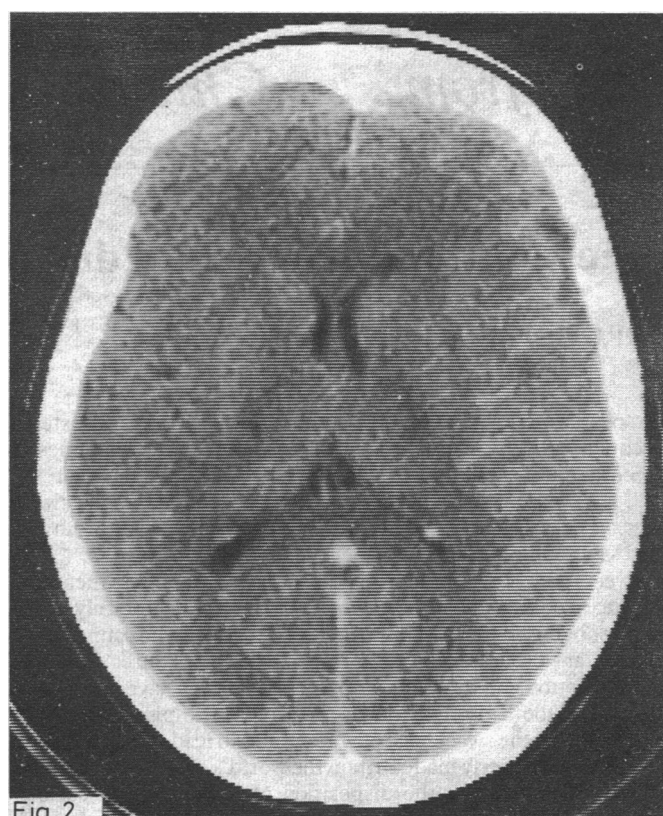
Case 3. CT scan in subdural empyema showing slight midline shift and hypodense area in left temporal region.
